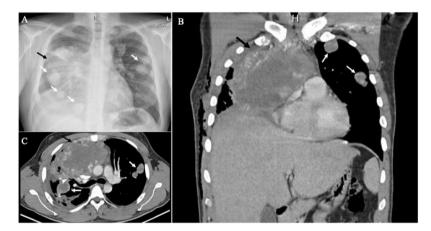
(A) Thoracic X-ray showing a heterogenous right-sided mass continuous to the mediastinum (black arrow) and multiple pulmonary well-defined opacities (white arrows); (B) Coronal section on thoracic CT-scan showing a heterogeneous solid mediastinal mass (black arrow), touching the right atrium and diaphragm, and two pulmonary solid nodules on the left lung (white arrows); (C) Axial section on thoracic CT-scan presenting the anterior mediastinal mass (black arrow) contacting the ascending aorta, and left and right pulmonary nodules suggesting various metastasis (white arrows).
